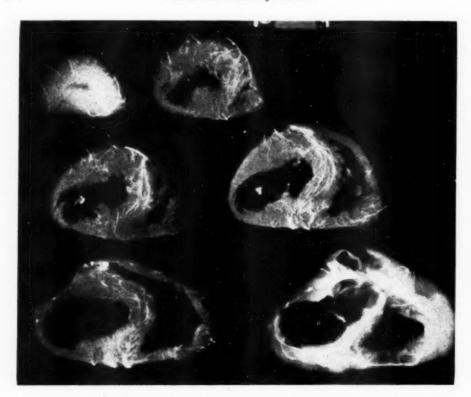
Roentgenogram of the injected heart in Case 158 with a large, healed lateral infarct demarcated by the avascularity and thinning of the wall.
